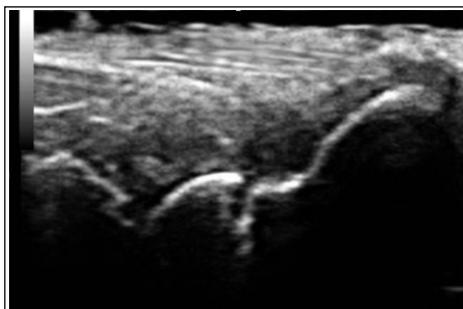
CEO Medical Records. Identification of focus of unconsolidated fracture of scaphoids under ultrasound vision.
